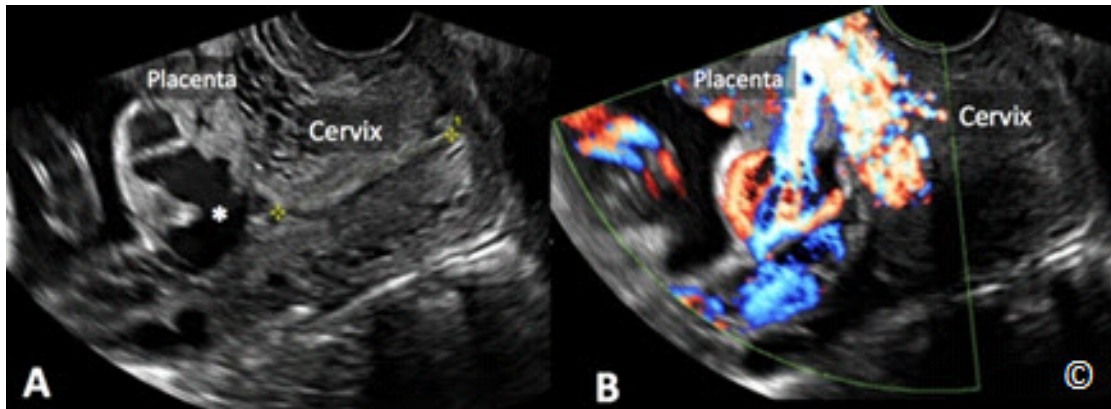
A and B: Transvaginal ultrasound in grey scale (A) and color Doppler (B) in a patient with placenta accreta. Note the presence of large placental lacunae (asterisk in A) and color Doppler showing extensive vascularity in B. Cervix and placenta are labeled.
